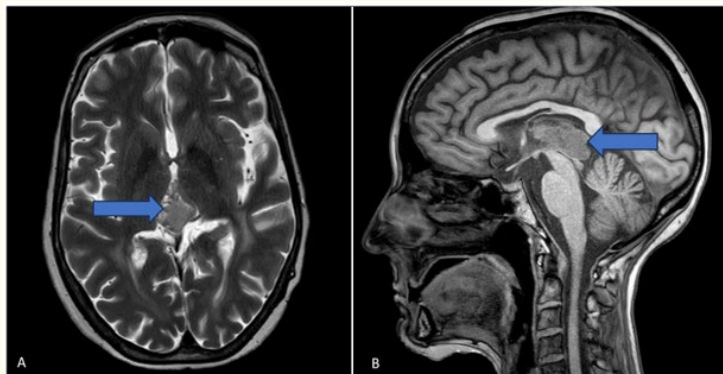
Pineoblastoma in 16 years old. MRI shows a well-circumscribed uncapsulated tumor, with lobulated contours arising from the pineal region (arrows) (A): Axial T2-weighted image shows that the tumor is intermediate to high signal relative to gray matter. (B) Sagittal T1 image shows that the tumor is isointense to grey matter. In this view, the mass appears compressing the tectal plate and the dorsal midbrain without clear obstruction of the cerebral aqueduct.
